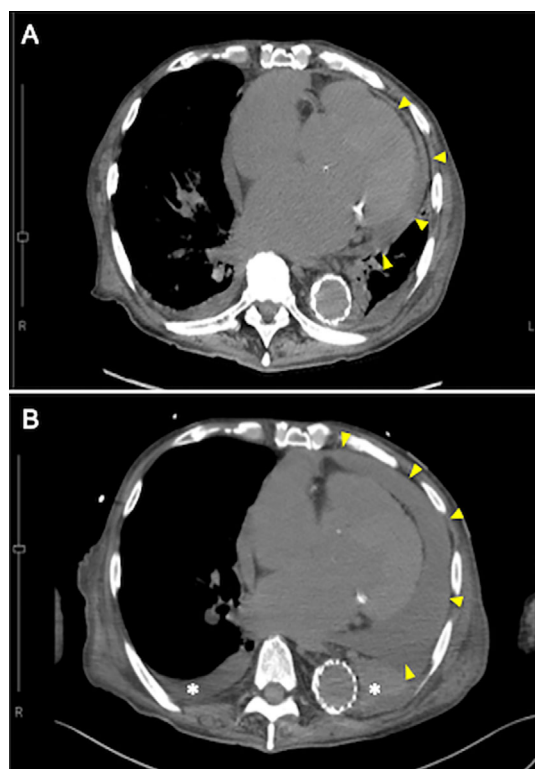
Pericardial effusion detected by computed tomography. A: Slight pericardial effusion was detected by nonenhanced computed tomography (CT) on day 3 (arrowheads). B: Follow-up CT was performed on day 9 because of deterioration of the patient's general condition. The amount of pericardial effusion dramatically increased over six days (arrowheads). Bilateral pleural effusion became evident (asterisk).
